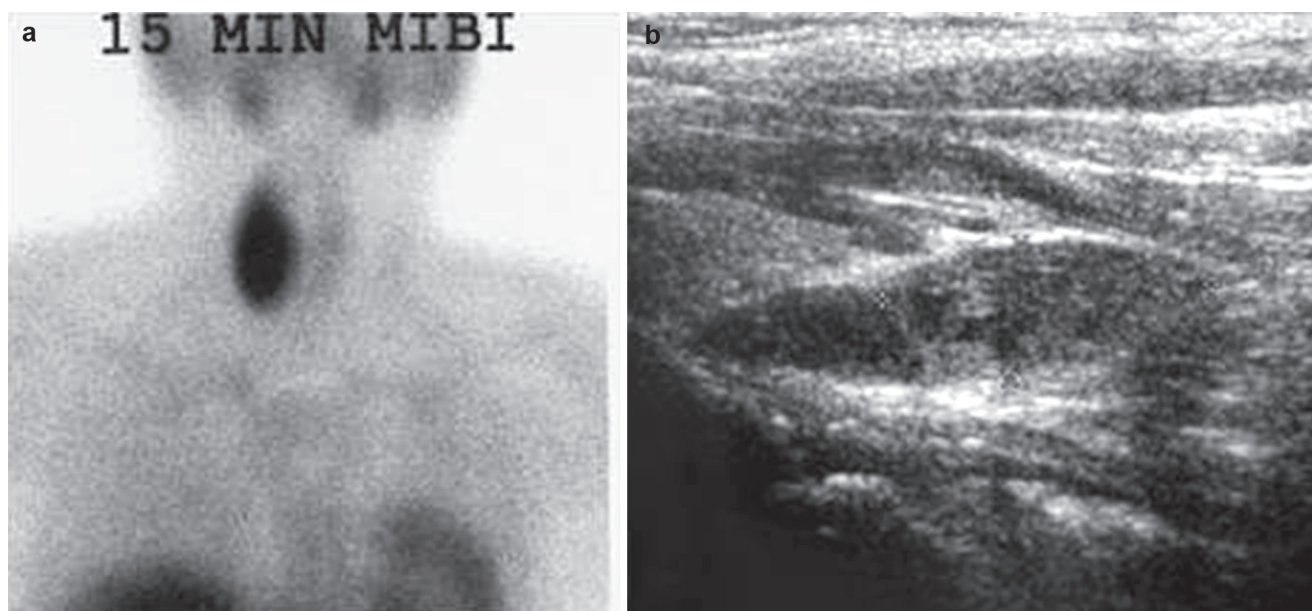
Concordant scans: (a) sestamibi and (b) ultrasound
